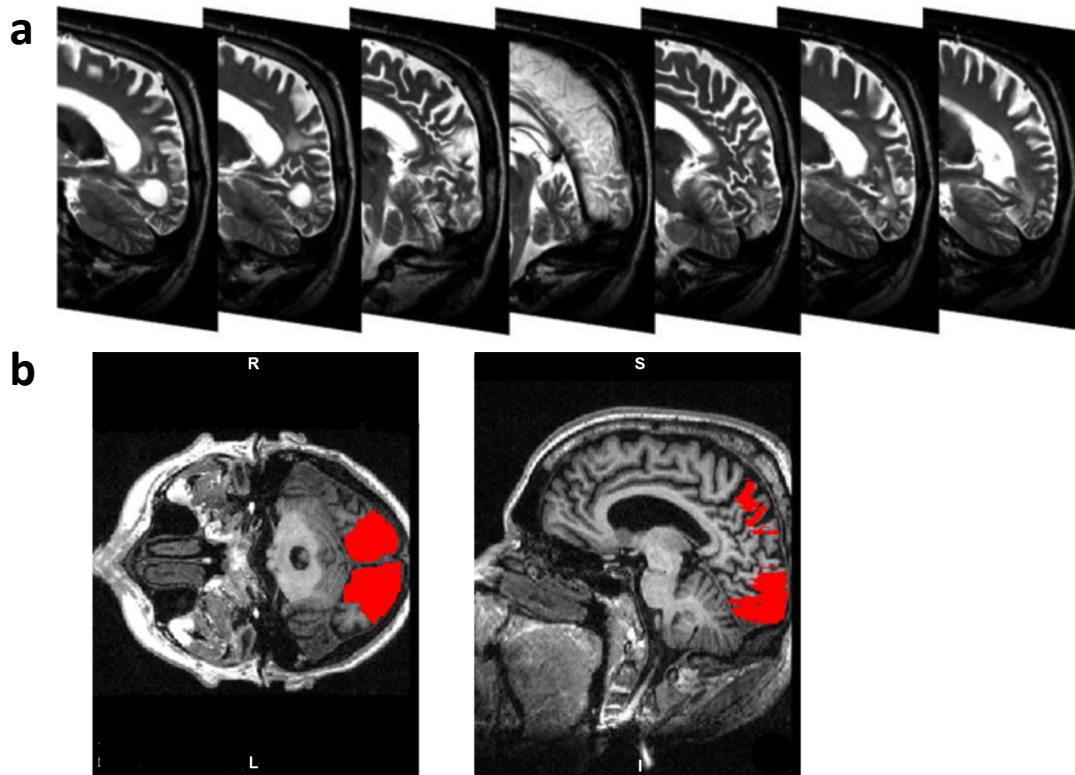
Structural MRI and lesion analysis. (a) Sagittal view of SDV’s MRI scans. (b) Lesion region of interest (in red) that was used as an explicit mask in the statistical analysis.
